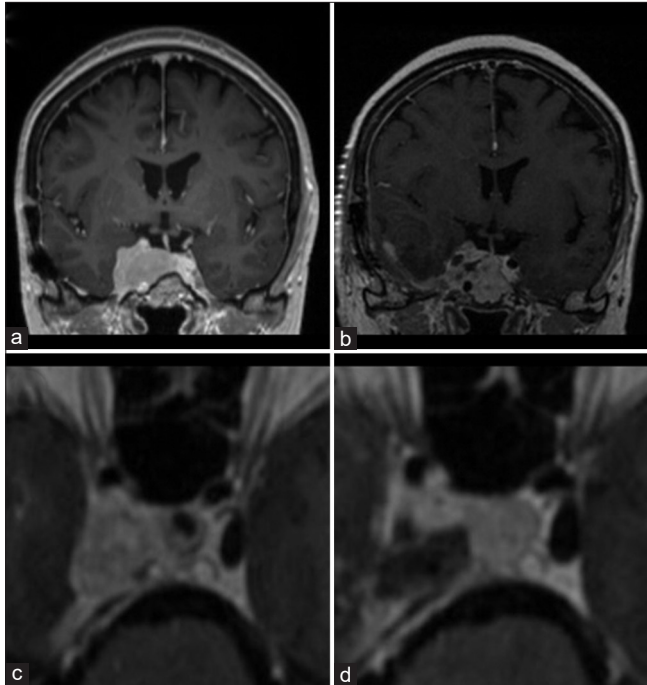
Pre- and postoperative coronal T1 contrast-enhanced magnetic resonance imaging. (a) Initial magnetic resonance (MR)-imaging revealed a homogeneously contrast enhancing lesion of the right cavernous sinus consistent with cavernous sinus meningioma. (b) Three months after surgery, MR-imaging revealed no extracavernous residual tumor.
